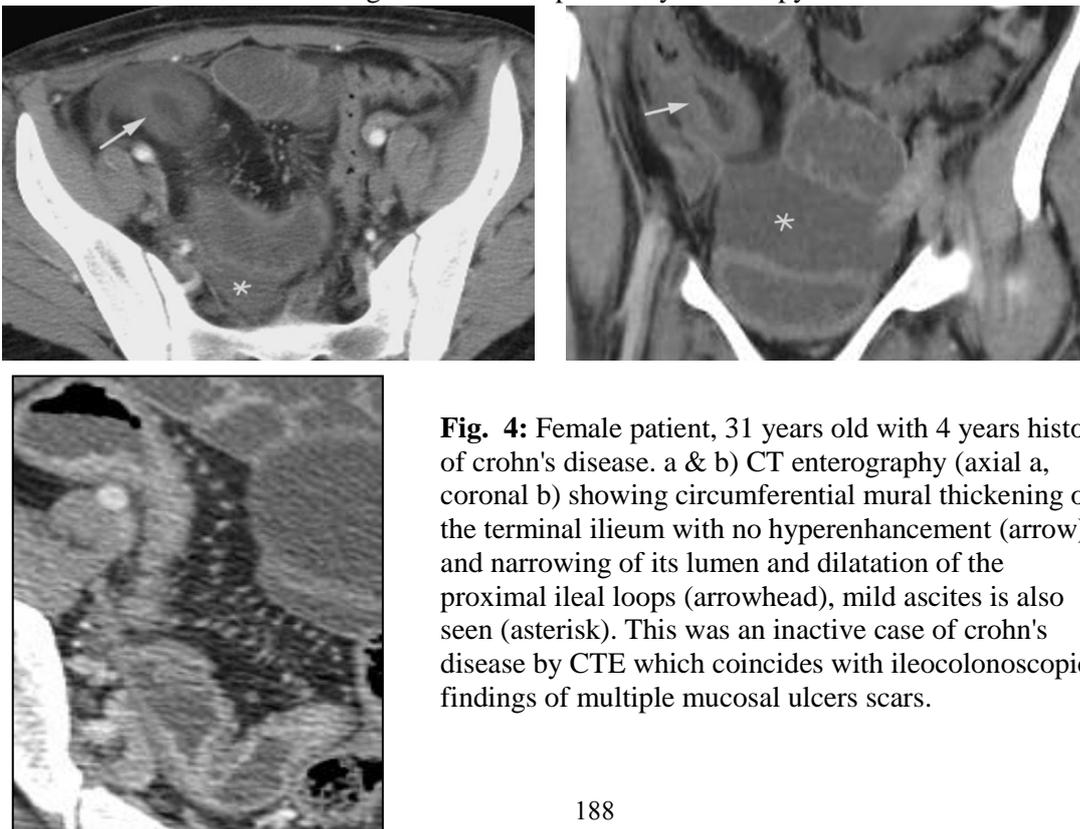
Female patient, 31 years old with 4 years history of crohn's disease. a & b) CT enterography (axial a, coronal b) showing circumferential mural thickening of the terminal ileum with no hyperenhancement (arrow) and narrowing of its lumen and dilatation of the proximal ileal loops (arrowhead), mild ascites is also seen (asterisk). This was an inactive case of crohn's disease by CTE which coincides with ileocolonosopic findings of multiple mucosal ulcers scars.
